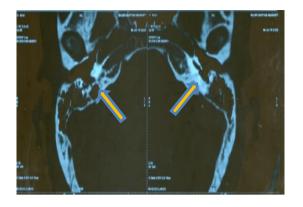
Temporal Bone CT Scan Image
